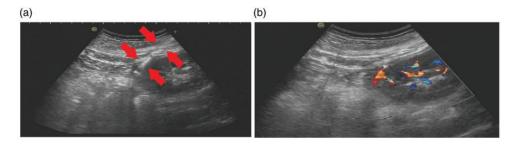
Representative Doppler ultrasonography images showing the puncture needle within the kidney (red arrows) (A) and active bleeding along the needle path toward the ultrasound probe after the puncture needle was withdrawn from the kidney during percutaneous renal biopsy (B). The colour version of this figure is available at: http://imr.sagepub.com.
